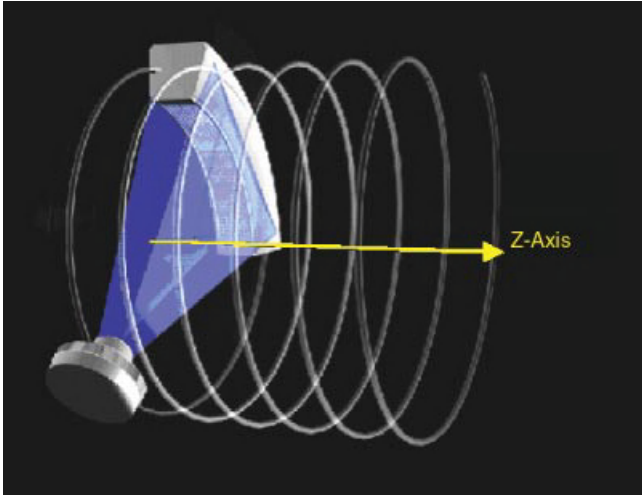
Principle of spiral/helical CT scanning: the patient table is continuously translated while multiple rotations of scan data are acquired. The path of the X-ray tube and detector relative to the patient is a helix. An interpolation of the acquired measurement data has to be performed in the z-direction to estimate a complete CT data set at the desired image position.
